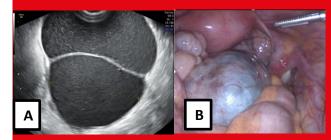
Ovarian endometrioma seen in Ultrasound (A) and laparoscopy (B).
